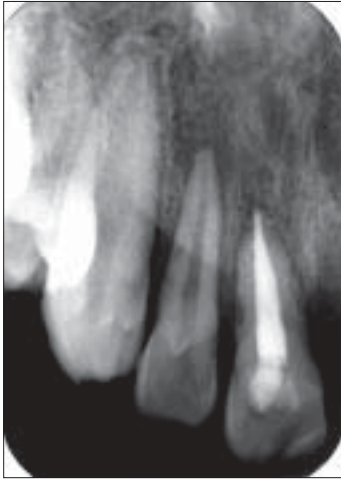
Intra oral periapical radiograph taken after completion of endodontic treatment of 11.
